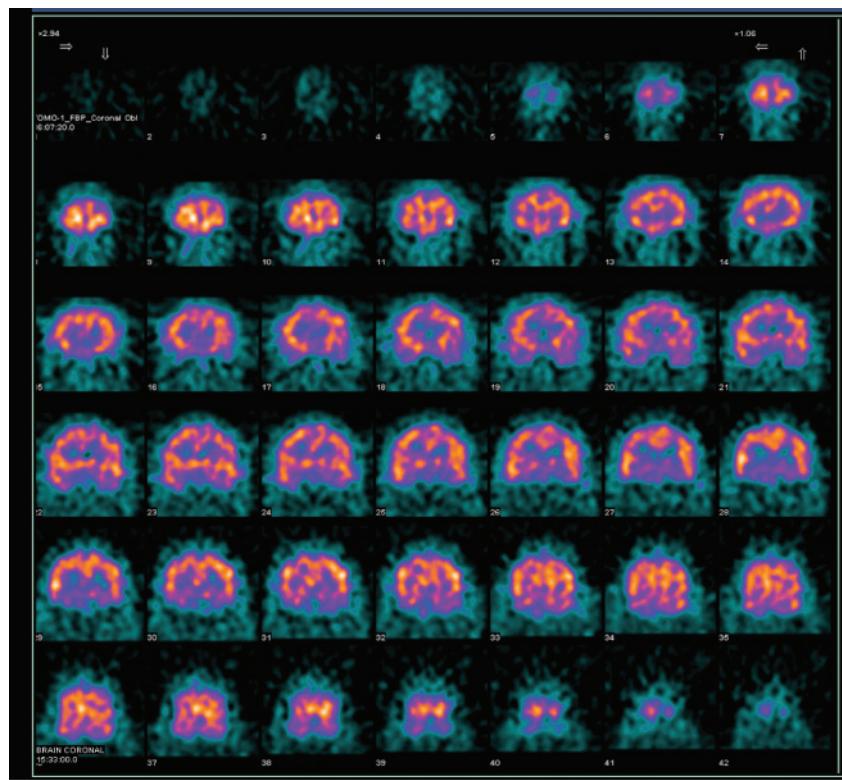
Coronal view of brain SPECT
